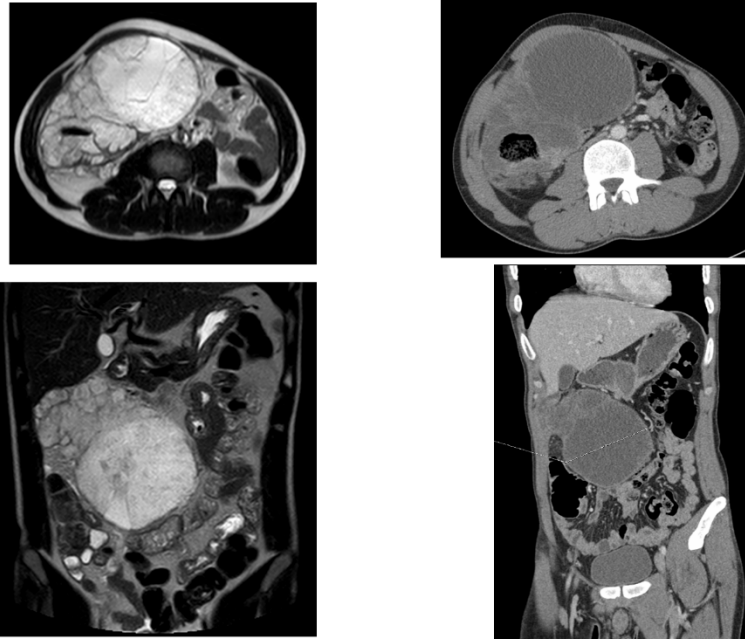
CT and MRI scan imaging showing a heterogeneous multi-septate cystic mass dependent on the hepatic colon flexure.
